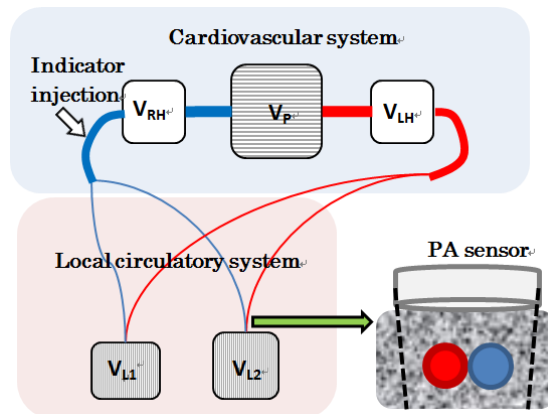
The simple scheme of PA indicator dilution measurements with a flat ultrasound transducer is shown. V_{RH} : right atrium, V_P : vascular volume for right, left ventricles, and pulmonary blood vessels, V_{LH} : left atrium, and V_L : capillaries in the local circulatory system. For a PA indicator dilution curve, both the artery (red circle) and vein (blue circle) are measured by the PA sensor.
